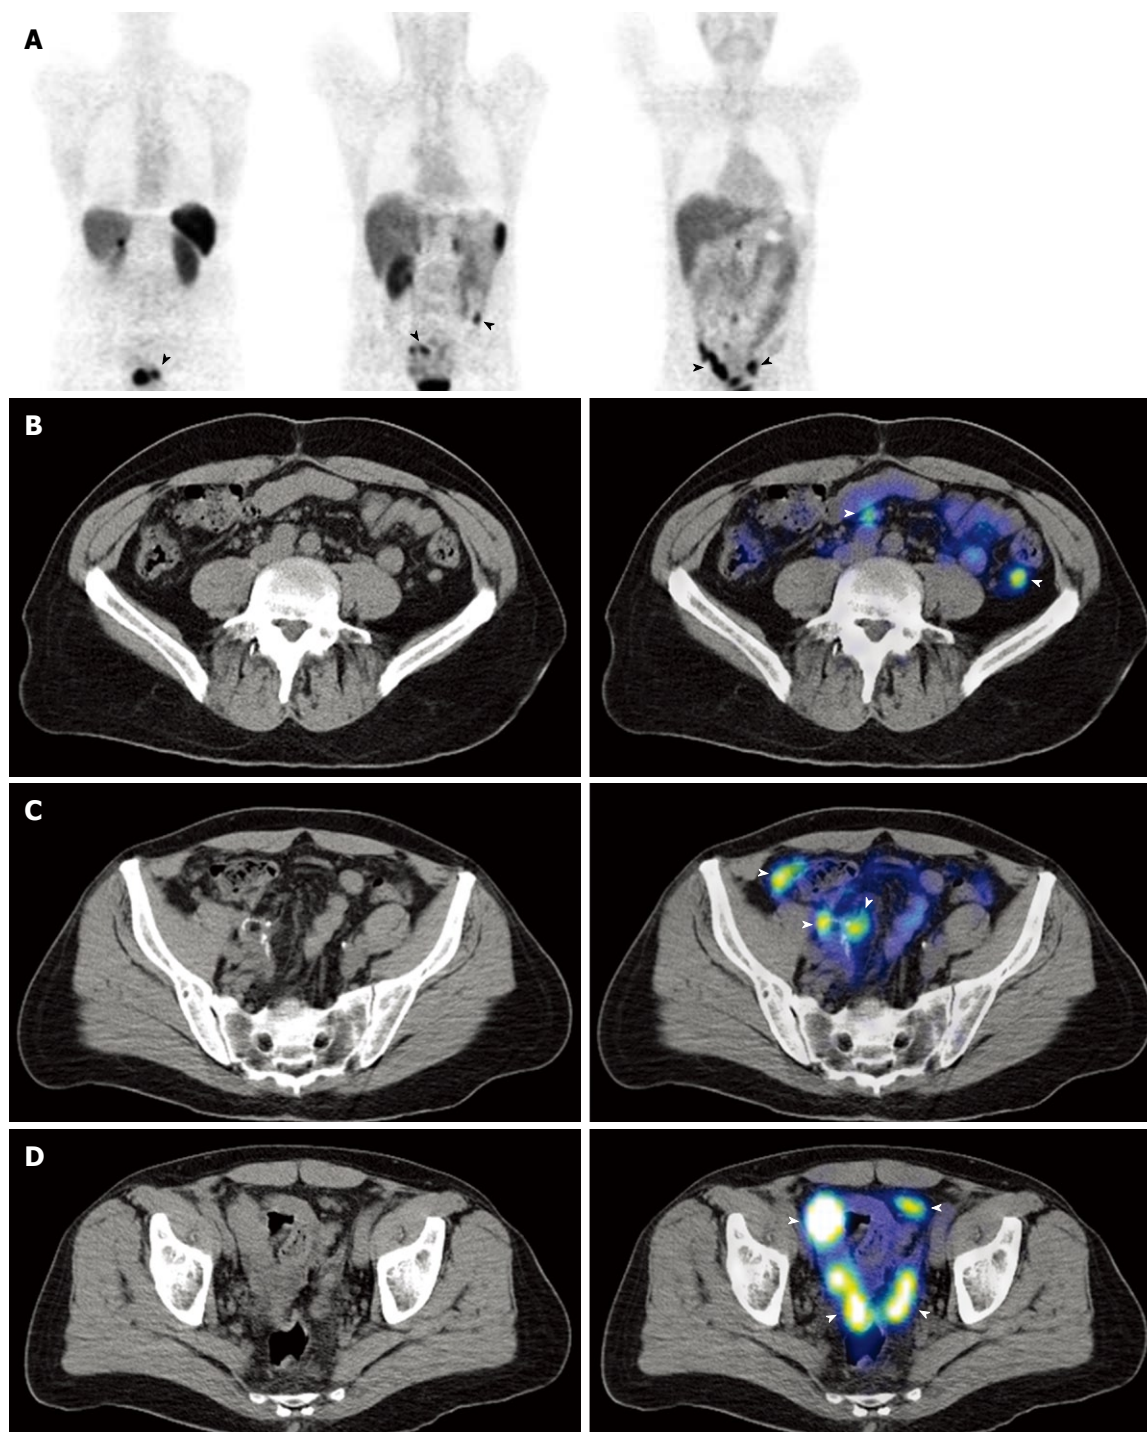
Metastatic appendiceal neuroendocrine carcinoma with multiple peritoneal deposits. A: Coronal PET images demonstrate multiple tracer avid foci projected over the abdomen and pelvis (black arrowheads); B-D: Axial CT and PET/CT sections of the abdomen show multiple somatostatin receptor rich peritoneal deposits (white arrowheads).
